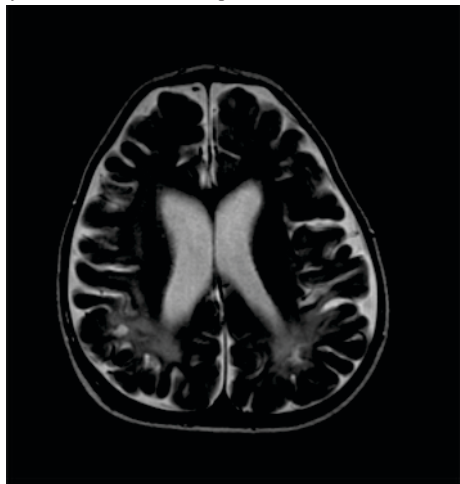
MRI Axial T2w Image Demonstrating Periventricular Leucomalacia
